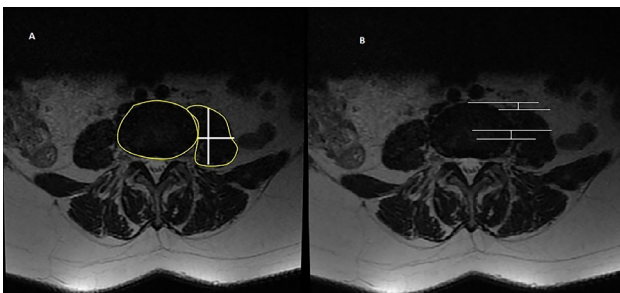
Analysis of psoas muscle cross-sectional areas at L2-3, L3-4 and L4-5 intervertebral disc levels in lumbar magnetic resonance imaging (A) Psoas muscle anteroposterior length/medial-lateral width ratio and cross-sectional area (each measured cross-sectional area is divided by the cross-sectional area of the intervertebral disc at the same level to minimize differences based on individual physical characteristics and gender). (B) Evaluation of the position of the psoas muscle relative to the intervertebral disc in the axial plane. The measurement includes the vertical distance between the anterior edge of the psoas muscle and the anterior edge of the intervertebral disc, as well as the vertical distance between the midpoints of the psoas muscle and the midpoints of the intervertebral disc. The distance is recorded as positive (+) if the anterior edge or center of the psoas muscle is more anterior than the intervertebral disc, as negative (-) if it is further back
